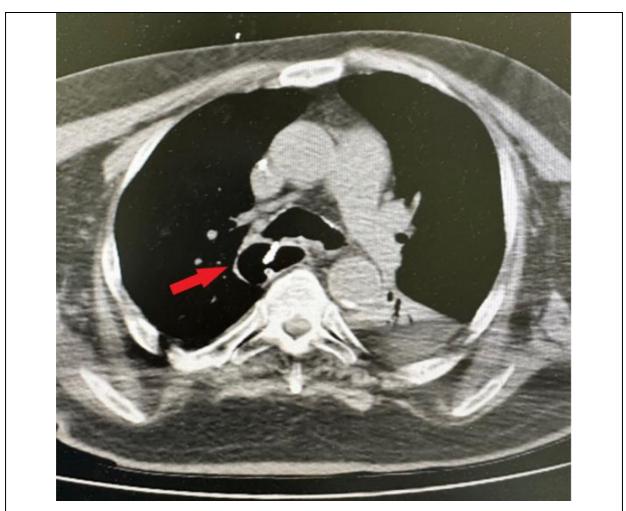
The initial CT scan showing the tracheoesophageal fistula and the clips placed during the EGD (red arrow).
